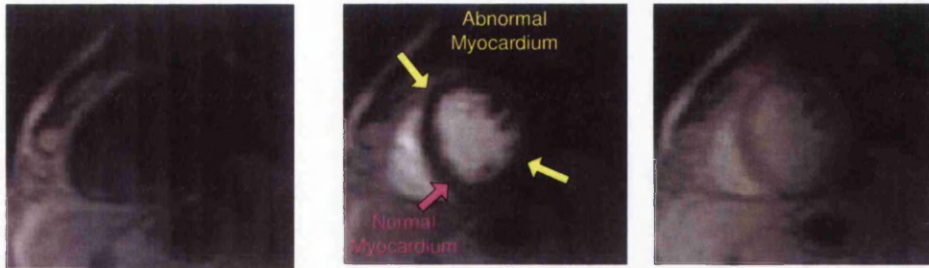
The Analysis of first pass perfusion MR images. The images were acquired in the short axis view after injecting the contrast enhancing agent, Gd-DPTA. The arrows point to the normal and the abnormal myocardium. The perfusion curves were produced by using Angus (Siemens medical systems).
